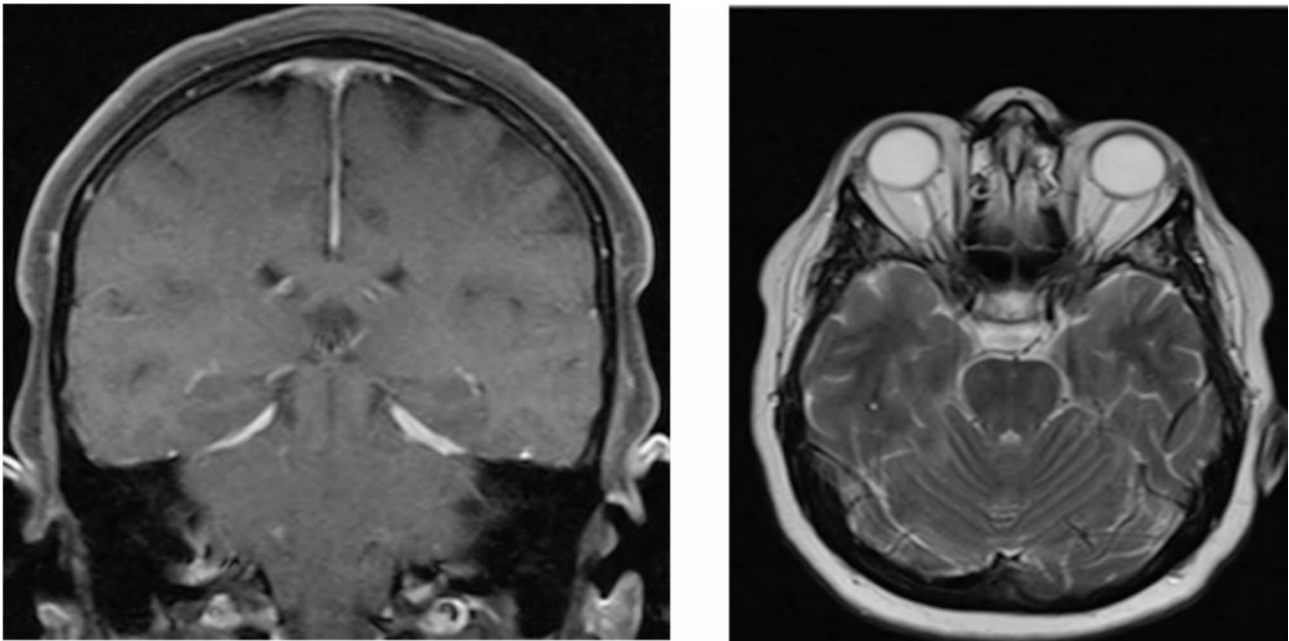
Brain MRI with gadolinium of case 1: (left) meningeal enhancement; (right) increased ONSD
